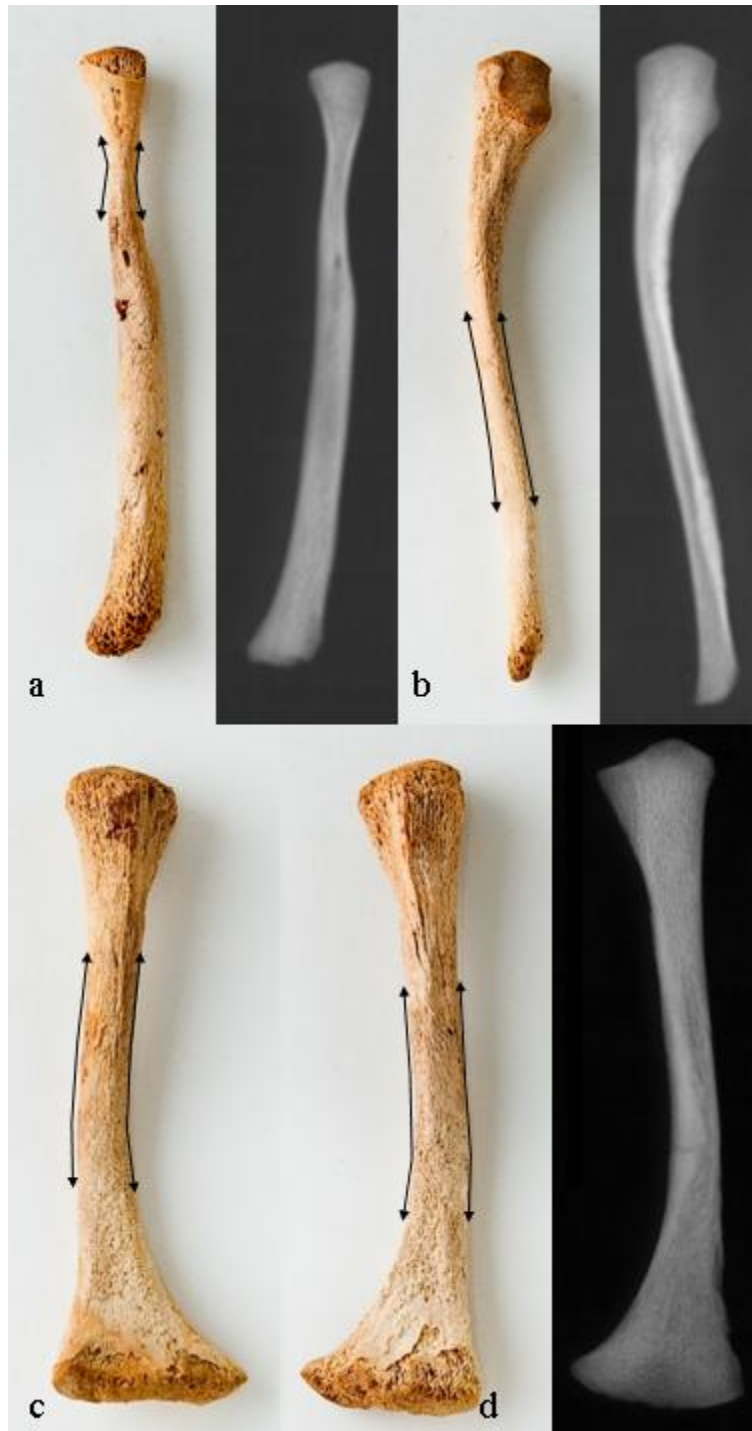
Long bones of B532 with narrowing of the diaphyses. Arrows indicate the narrow diaphyses, but this is more clearly evident on the radiographs. a) right radius, anterior view; b) right ulna, anterior view; c) right humerus, anterior view; d) left radius, anterior view.
